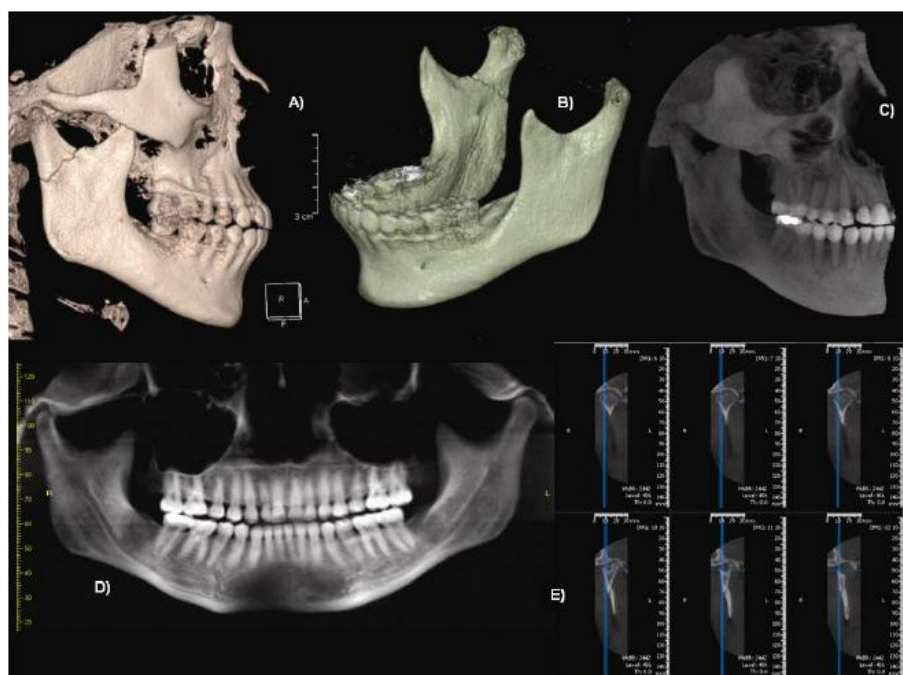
TMJ complex by using CBCT
